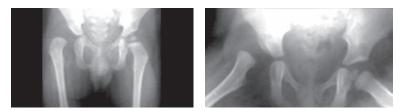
AP and frog pelvis radiographs shows congenital hip dislocation in a 3-year-old male
